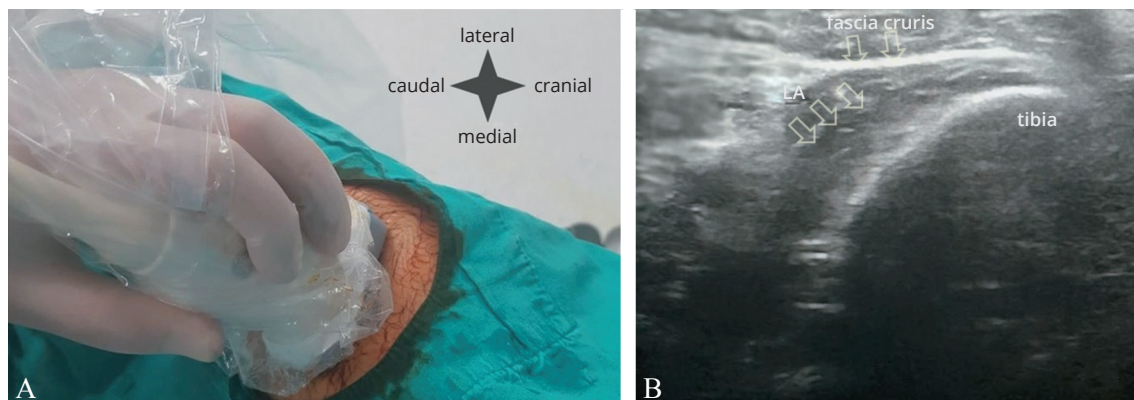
A) Patient and probe position. A high-frequency 12 MHz linear US probe was placed on the tibia at approximately 10 cm proximal to the ankle joint; B) sonographic anatomy, and spread of local anesthetic. Spread of LA is seen between fascia cruris and periosteum.
